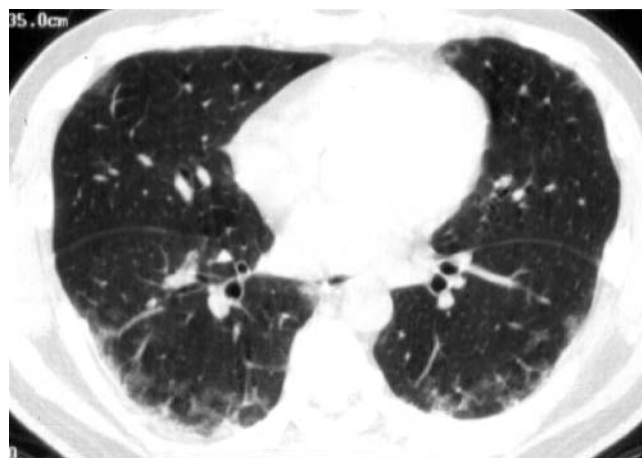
High-resolution CT image of the lungs, showing subpleural funicular opacities and consolidation in both lungs.
